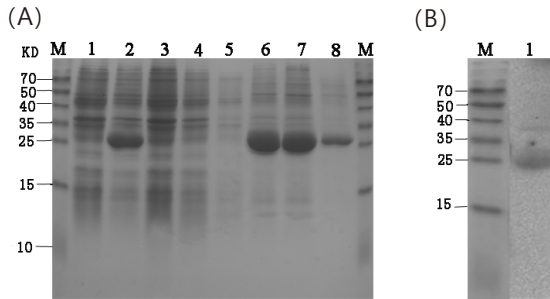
Expression, purification, and identification of the rPhoY2 protein. (A) Expression and purification of the rPhoY2 protein. Lane M, protein marker (kDa); lane 1, recombinant bacteria without induction control; lane 2, induced recombinant bacteria whole cell lysate with IPTG; lane 3, supernatant after ultrasonic disruption of induced recombinant bacteria with IPTG; lane 4, protein eluate from nickel column chromatography; lane 5, eluate after washing with 8 mol/l urea binding buffer; and lane 6–8, protein elution from nickel column chromatography. (B) Western blot analysis of the rPhoY2 protein. Lane M, protein marker (kDa); lane 1, purified rPhoY2.
